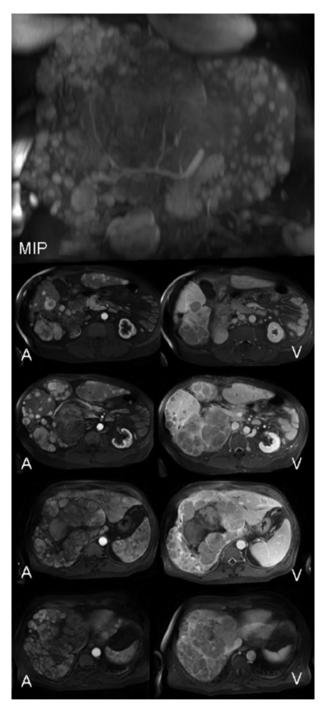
Magnetic resonance image with intravenous contrast media injection: oblique multi intensity projection (MIP) image acquired during the arterial phase shows multiple bilobar hypervascular lesions. The axial images show the hypervascular lesion visualized in the arterial phase (A), with corresponding washout in the venous phase (V.)
